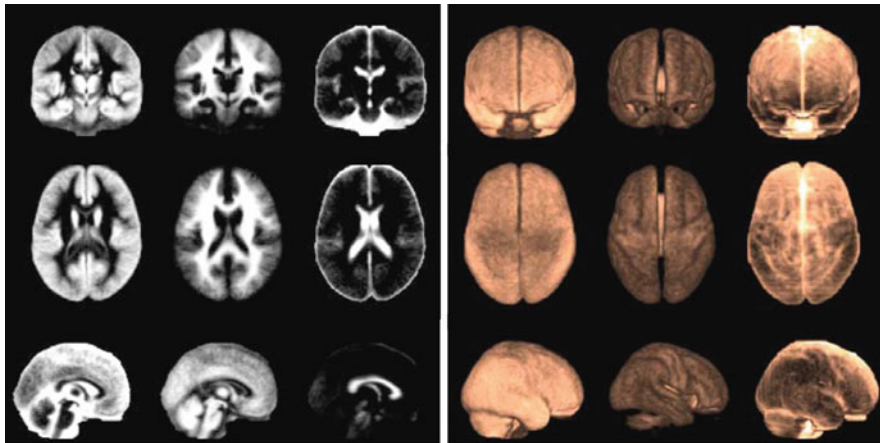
2D (left) and 3D (right) views of brain MRI atlas spatial information (gray matter, white matter, cerebrospinal fluid; coronal, axial, and sagittal)
